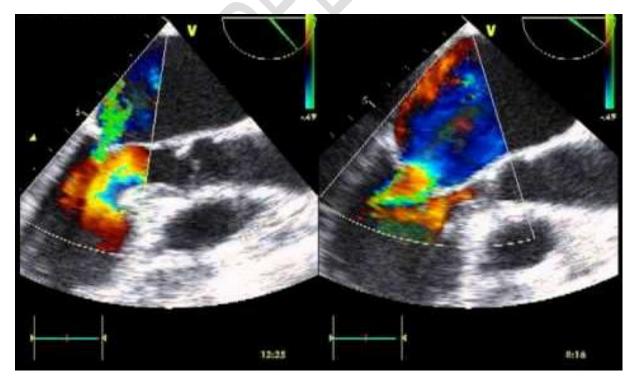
Echocardiogram of Acute Pulmonary Edema on Top of Mitral Regurgitation (14)
